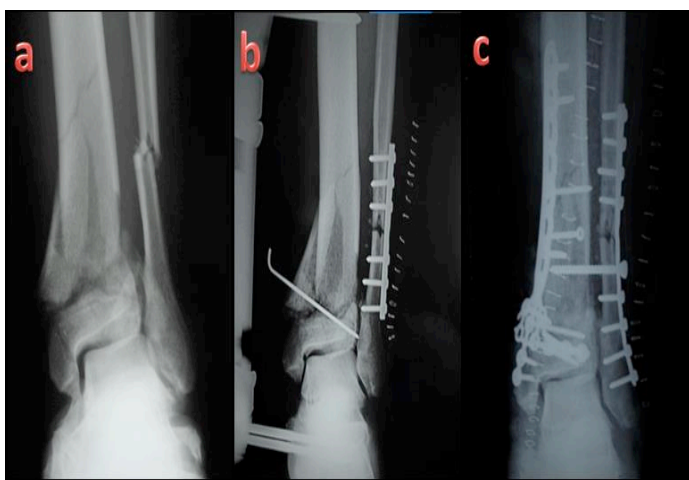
Staged fixation. a, Preoperative radiograph; b, First operation: EF+ Fibular plate; c, Early postoperative radiograph.
